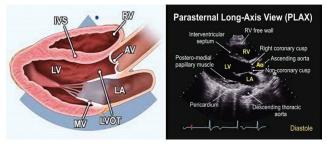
Parasternal Long-Axis View (LA-Left Atria, LV-Left Ventricle, RV-Right Ventricle, AV- Aortic Valve, IVS-Inter Ventricular Septum, MV-Mitral Valve, LVOT-Left Ventricular Outlet
